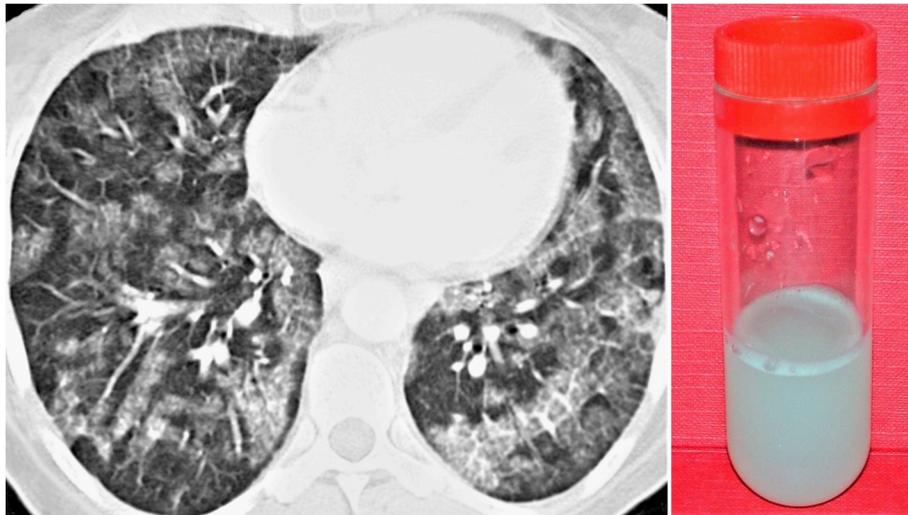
Left panel: CT-scan showing bilateral diffuse crazy paving patterns; Right panel: Opalescent milky bronchoalveolar lavage fluid.
